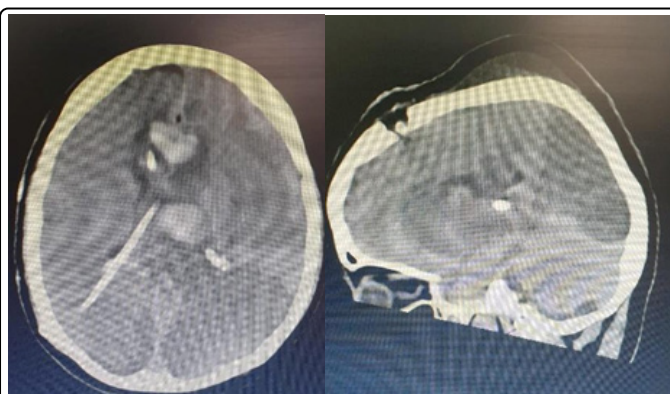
CT shows intraventricular bleed with ischemic changes in brain.
